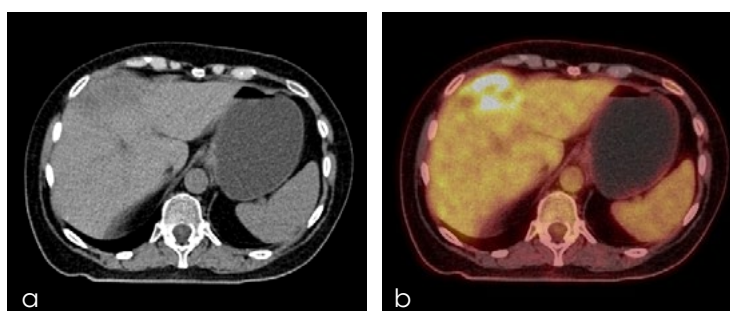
Contrast enhanced abdominal CT (a) and the PET/CT (b) after four DSM-TACEs show significant size reduction and a markedly decreased FDG uptake of the liver metastasis
